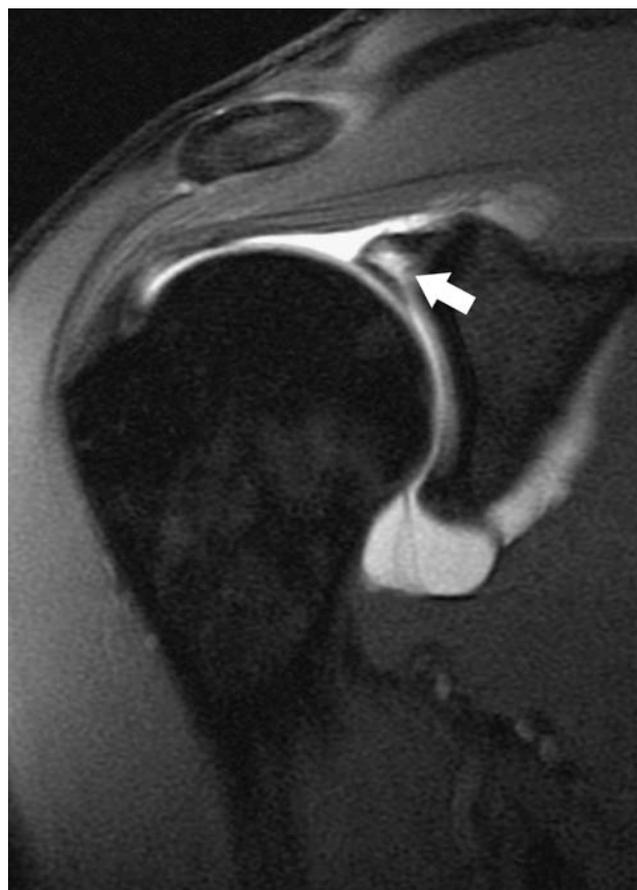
Superior labral tear. Coronal T1-weighted fat-saturated image of a shoulder MR arthrogram shows a linear hyperintense extension of gadolinium at the superior labrum (*arrow*)
